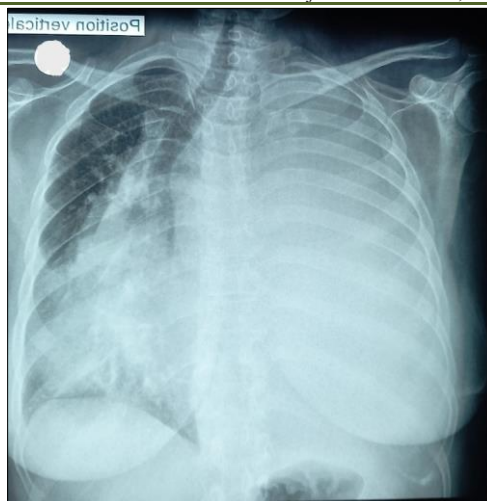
Chest X-ray showing a water-like opacity of the entire left hemithorax with displacement of the trachea and heart to the right
